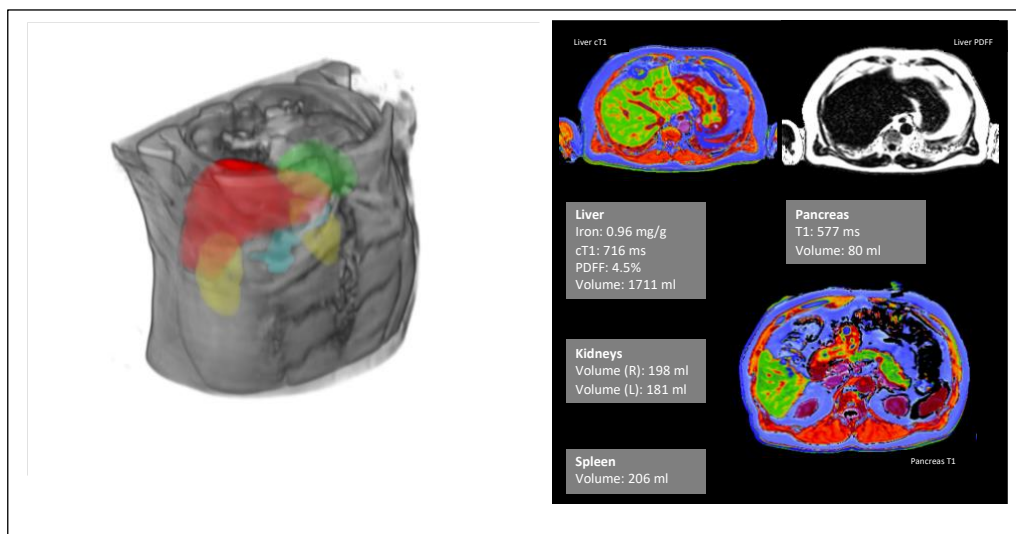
Example MRI images and metrics that are generated with ATLAS. Left panel shows liver (red), kidneys (yellow), pancreas (blue) and spleen (green) volume images within the thorax. Right panel shows single MRI slices with associated organ volume, fat infiltration or fibroinflammation metric values.
